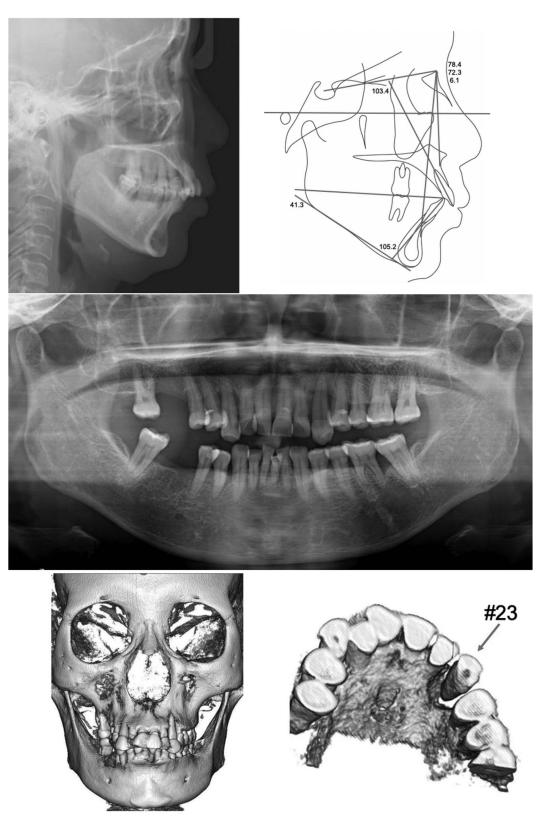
Pretreatment radiographs, cephalometric tracing, and three-dimensional reconstruction images.
